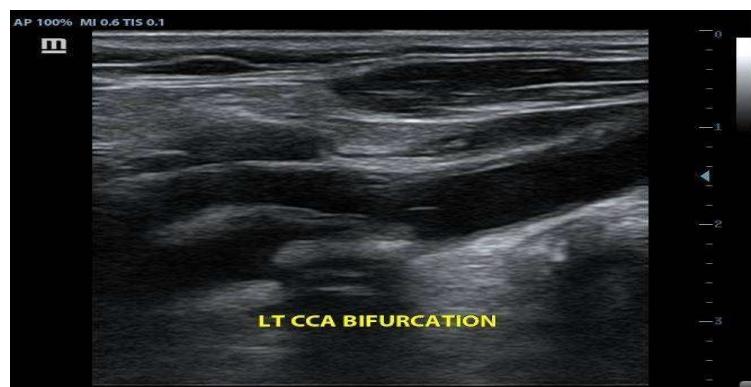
In same patient Longitudinal grey scale ultrasound images of left carotid artery shows echogenic plaque giving posterior acoustic shadowing noted in left ICA and causing significant stenosis
